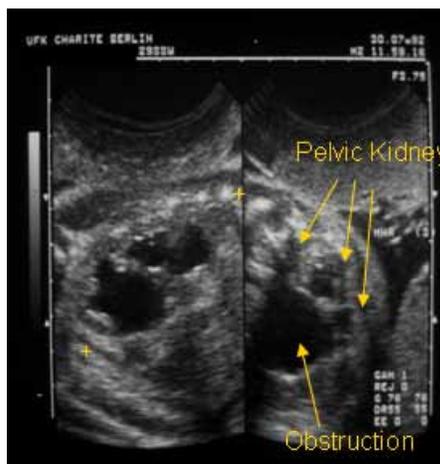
Prenatal ultrasound image of UPJ stenosis at the 16th (left) and 20th (right) week; renal pelvis diameter > 10 mm.
